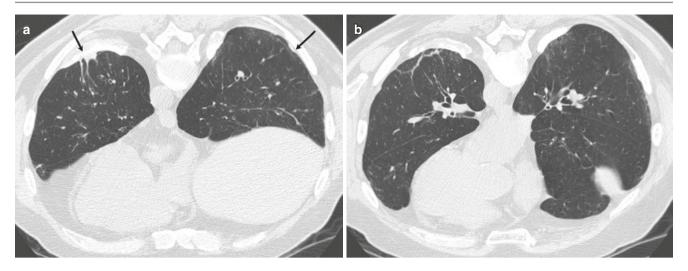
Early asbestosis. (a, b) Axial CT images show calcified pleural plaques (arrows) with curvilinear and perpendicular subpleural linear opacities representing earliest changes of asbestosis
